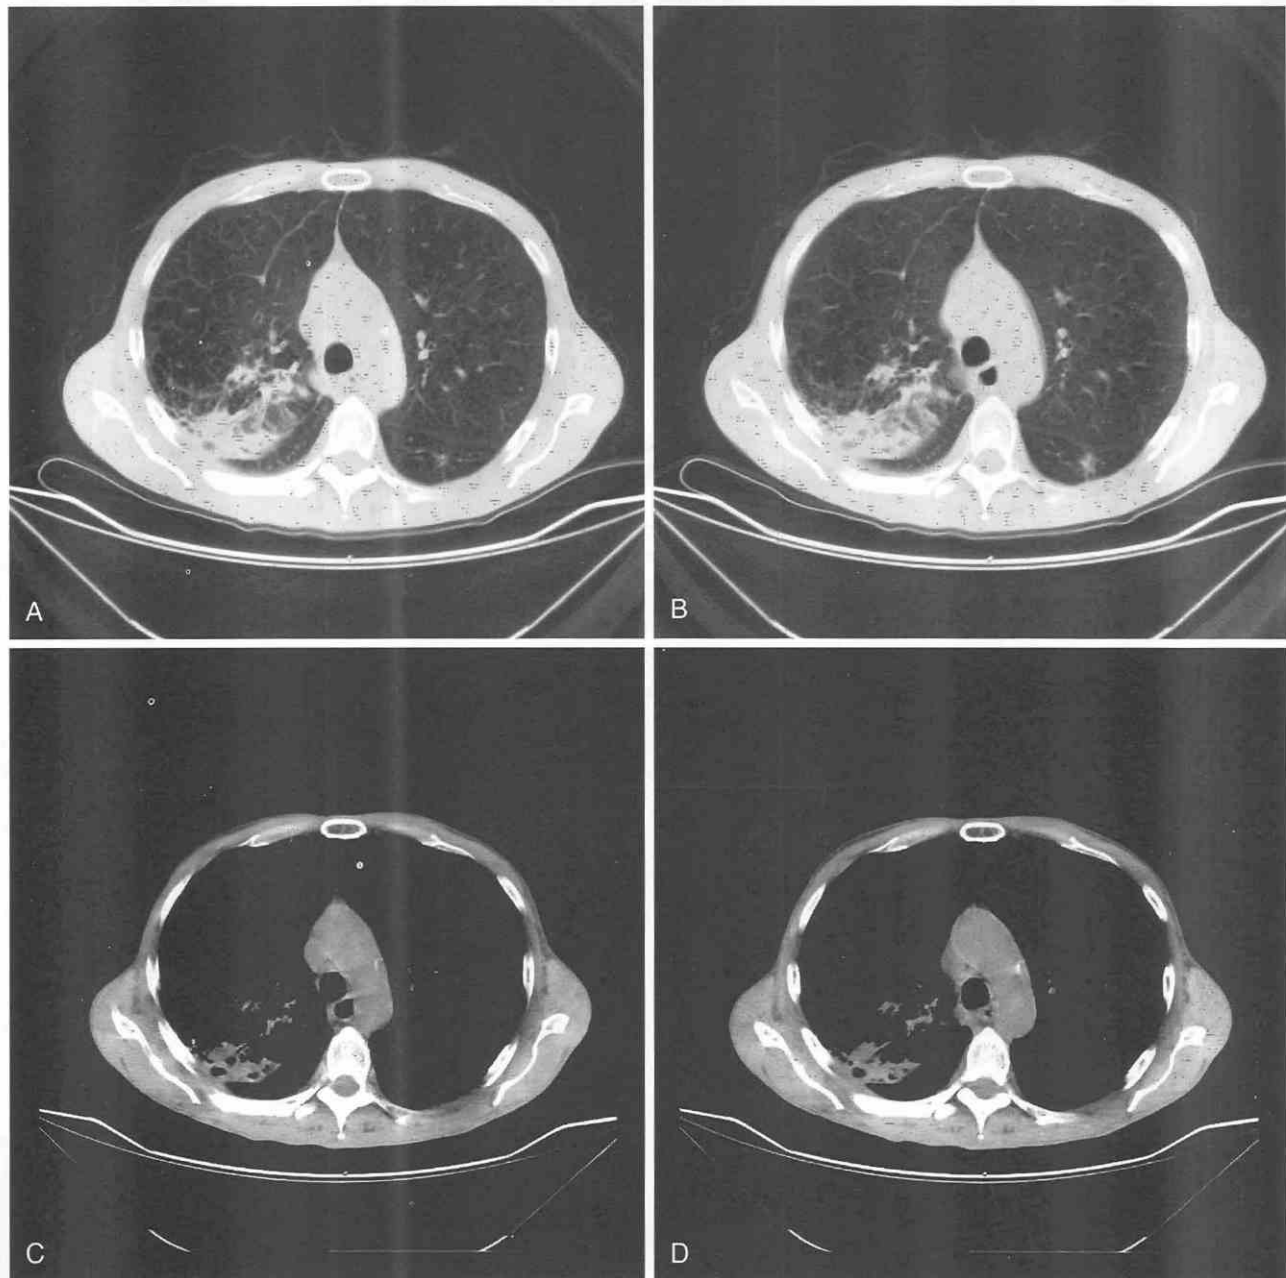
Lung scan demonstrating effects of extending spiral pitch with single-ring spiral CT. High spatial and z-axis resolution at pitch 1 (*A*) and pitch 2 (*B*). *C*, Same scan as *B* but windowed to demonstrate spiral pitch artifacts. *D*, Same scan as *A*, but windowed to demonstrate pitch artifacts. Note the increased spiral pitch artifacts at pitch 2 (*C*) versus those at pitch 1 (*D*).
